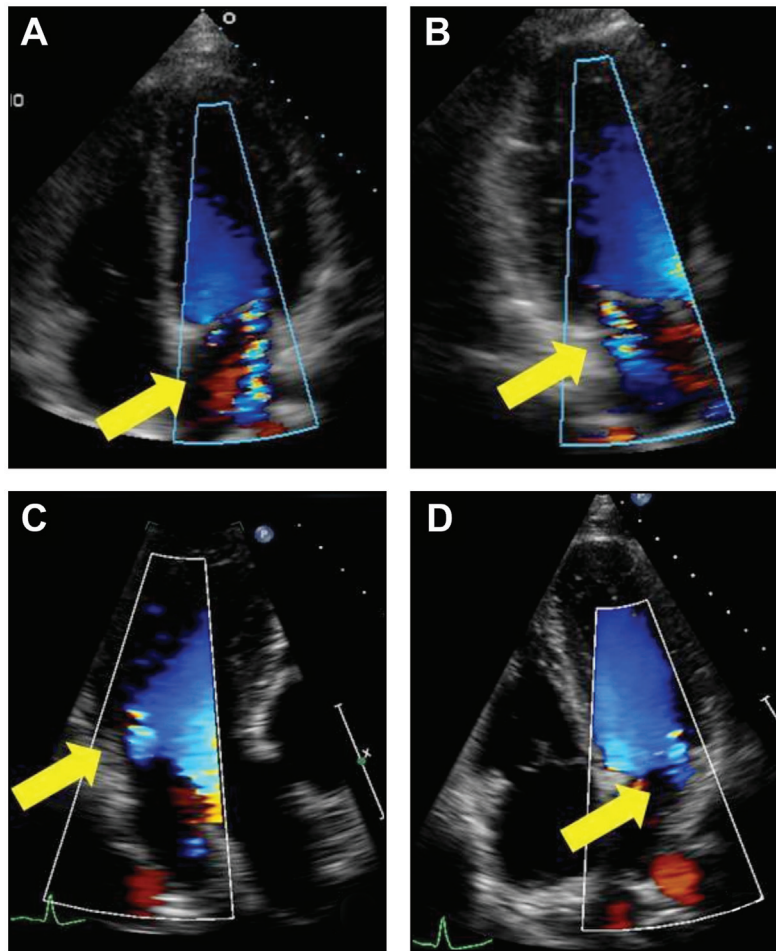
Echocardiograms: baseline (A and B) demonstrates apical displacement during systole with mild non-coaptation of the mitral leaflets and mild mitral regurgitation (arrows). Follow-up (C and D), 8 months after discontinuing cabergoline and starting bromocriptine, demonstrates a normal valve without mitral regurgitation (arrows).
